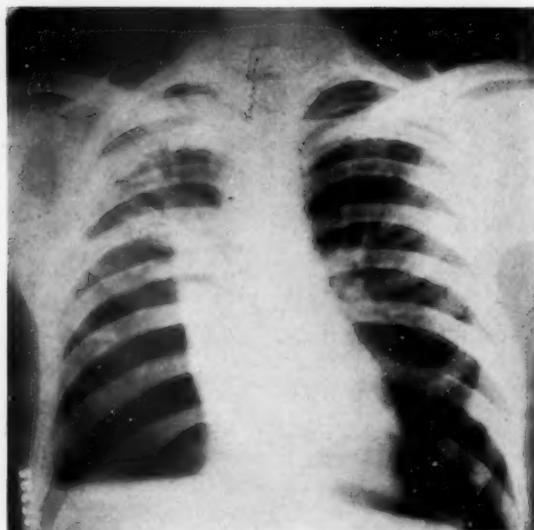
Case VI. Roentgenogram shows a hydro-pneumothorax on the right. The right upper half of the lung field is not collapsed because of an obliterative pleurisy. Within the uncollapsed portion of the lung there are numerous very small rarefied areas in the first interspace.
